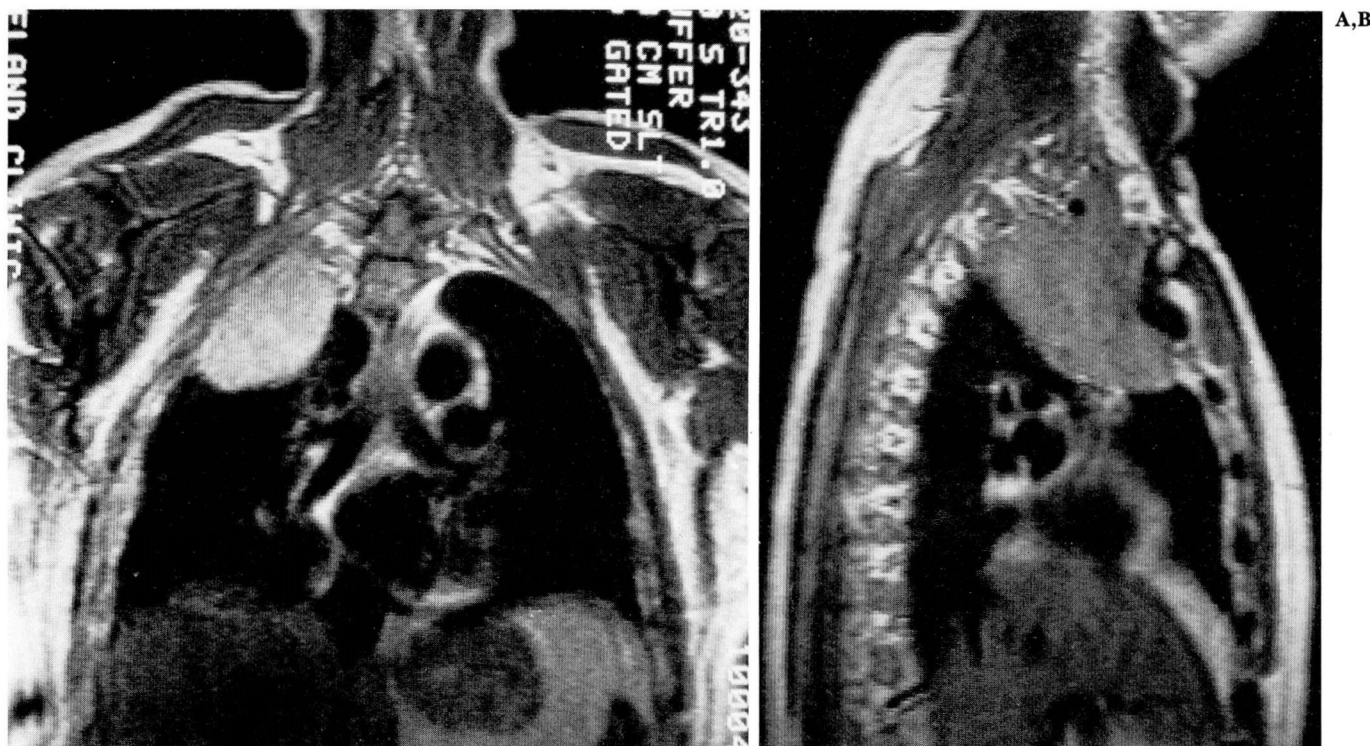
Plasmacytoma. Coronal (A) and sagittal (B) magnetic resonance images, TE 30/TR 500, show a large mass in the right lung apex extending into the base of the neck.
